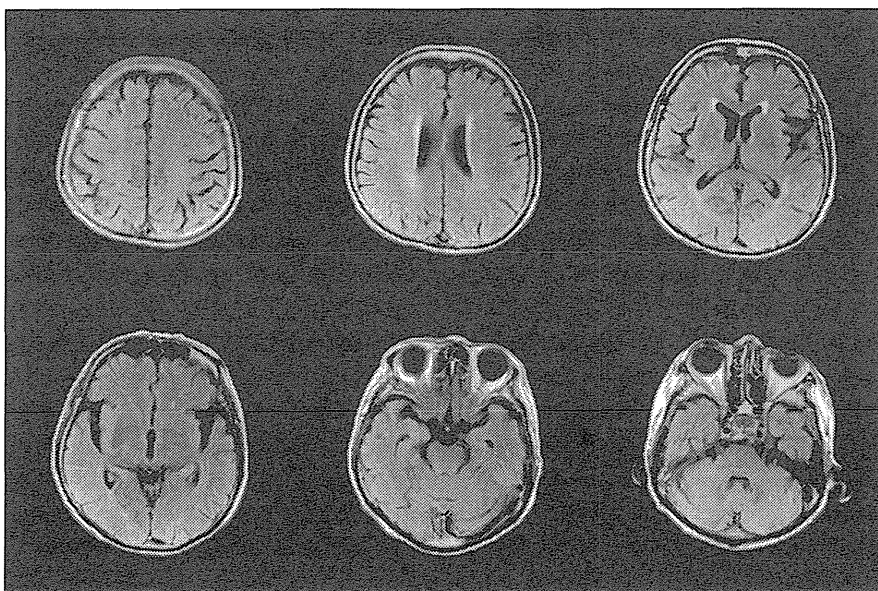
Fluid-attenuated inversion recovery view obtained during magnetic resonance imaging of a series of horizontal sections showing mild cortical atrophy.
